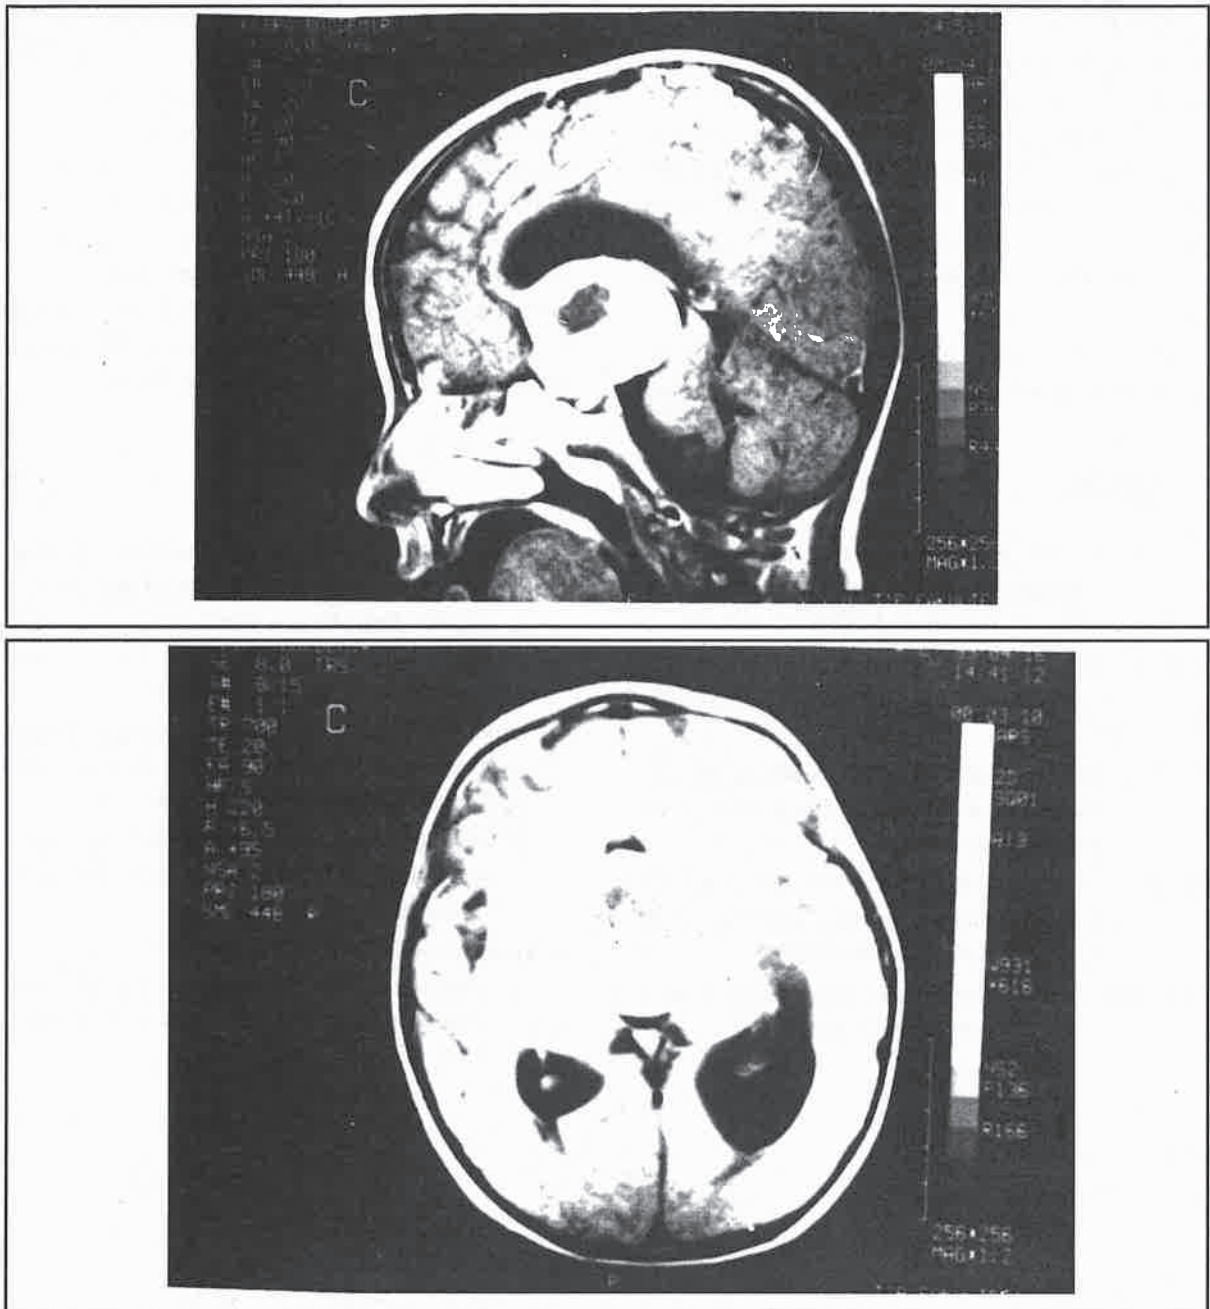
TIW MRI (a: sagittal, b: coronal) sections of the tumor enhanced after GDTA administration; the central hypointensity, indicating necrosis, should be noted.
